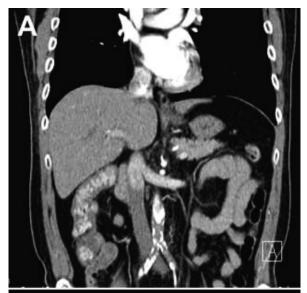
Computed tomography with contrast media revealed (A) Severe thrombosis with nearly total occlusion of the distal abdominal aorta involving bifurcation and bilateral proximal common iliac arteries. (B) Occlusion of distal abdominal aorta visible on cross-section (white arrow).
